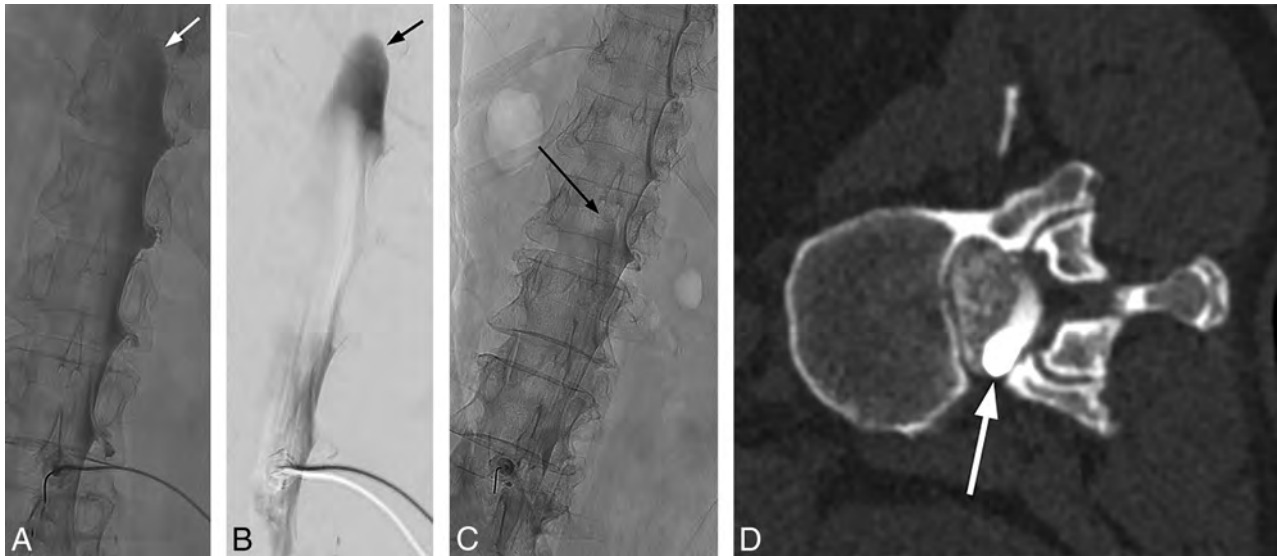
Mixed subdural and intrathecal injection. Unsubtracted (A) and subtracted (B) images from the DSM study demonstrate a subdural contrast injection superimposed on some intrathecal contrast. Note the masslike contrast extending cranially (arrows) rather than normal layering meniscus of intrathecal contrast. Unsubtracted image from the DSM study from another patient shows a small amount of masslike subdural contrast column extending cranially (C, arrow), which is confirmed on the subsequent decubitus CT myelogram (D, arrow).
